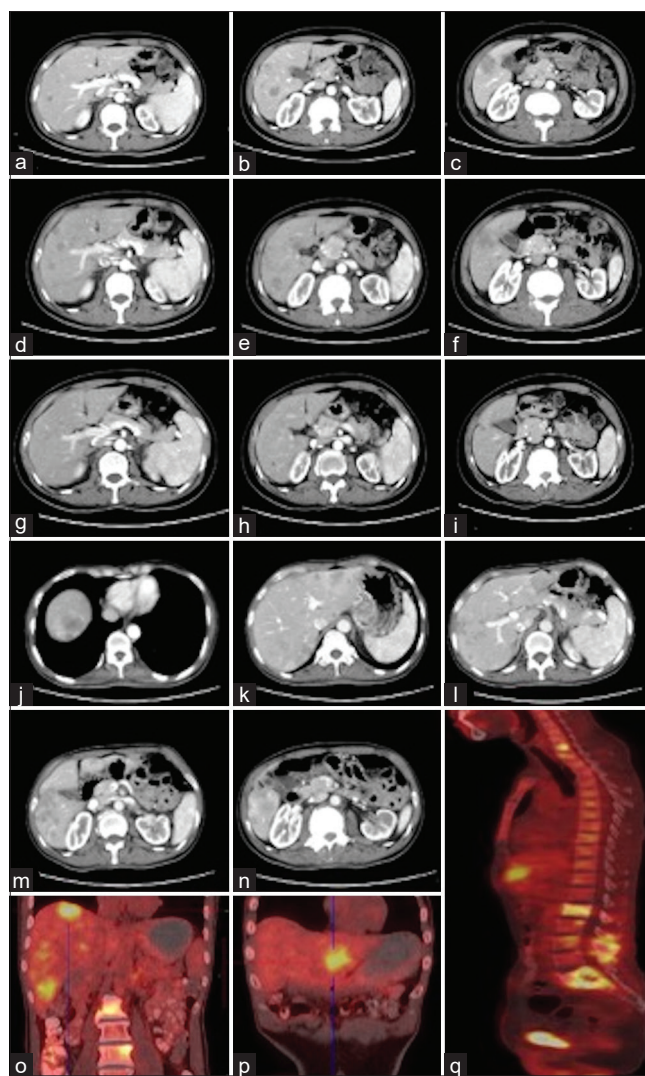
Computed Tomography (CT) and positron-emission tomography (PET) of liver metastasis and bone metastasis. (a-c), CT before Doc/Bev therapy, (d-f), CT before gemcitabine/cisplatin regimen re-challenge; (g-i), CT before pembrolizumab treatment; (j-n), CT after pembrolizumab; (o-p), PET after pembrolizumab; (q), PET after pembrolizumab
